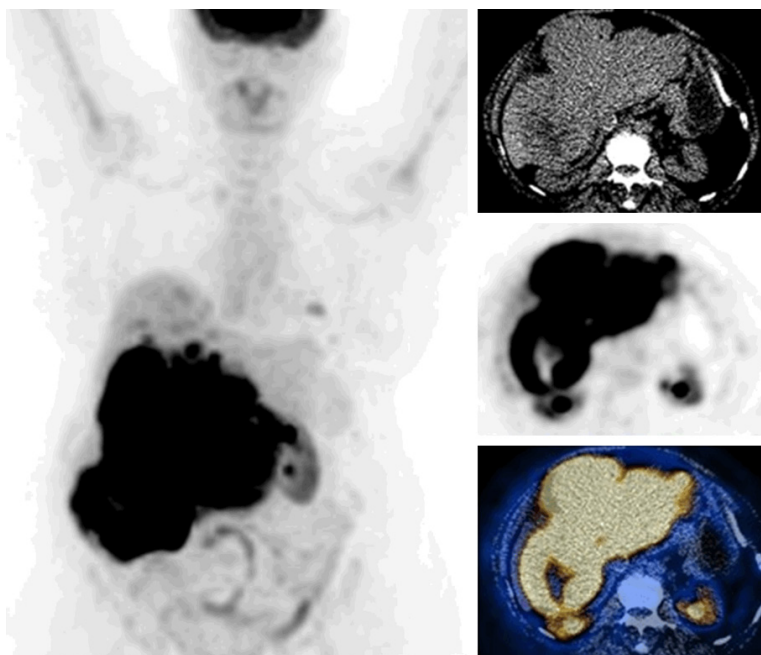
FDG PET/CT images of a case with primary liver sarcoma (whole body MIP, selected transaxial CT, PET, PET/CT fusion images of the liver). CT shows a large hepatic mass with heterogeneous density. PET shows marked hypermetabolic activity in the tumor (SUVmax: 27.5) and additional smaller foci in the liver parenchyma. Foci of mild uptake in the left lung are also seen, suspicious for metastases.
